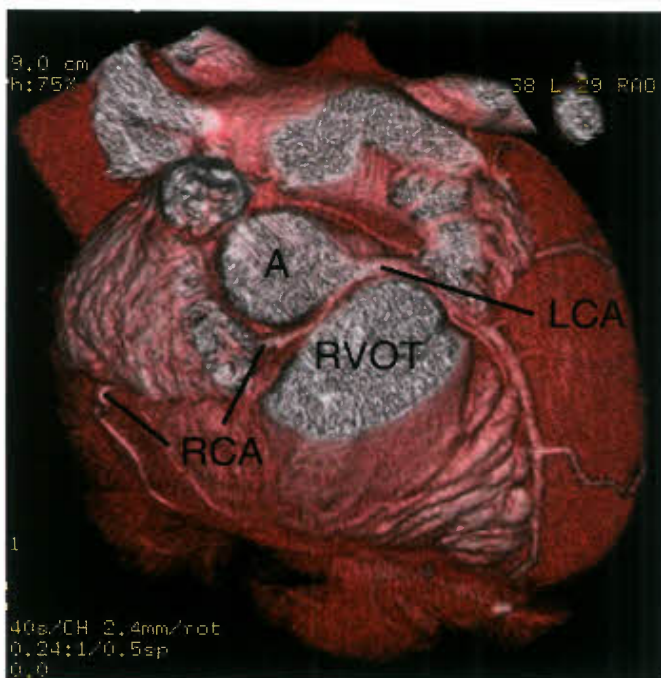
Three-dimensional reconstruction from computed tomographic imaging of the coronary arteries demonstrating anomalous origin of the right coronary artery from the left sinus of Valsalva, with oblique origin and course between the great arteries. Note the oblique origin of the right coronary artery, which then runs between the two great arteries. A, aorta; LCA, left coronary artery; RCA, right coronary artery; RVOT, right ventricular outflow tract.
